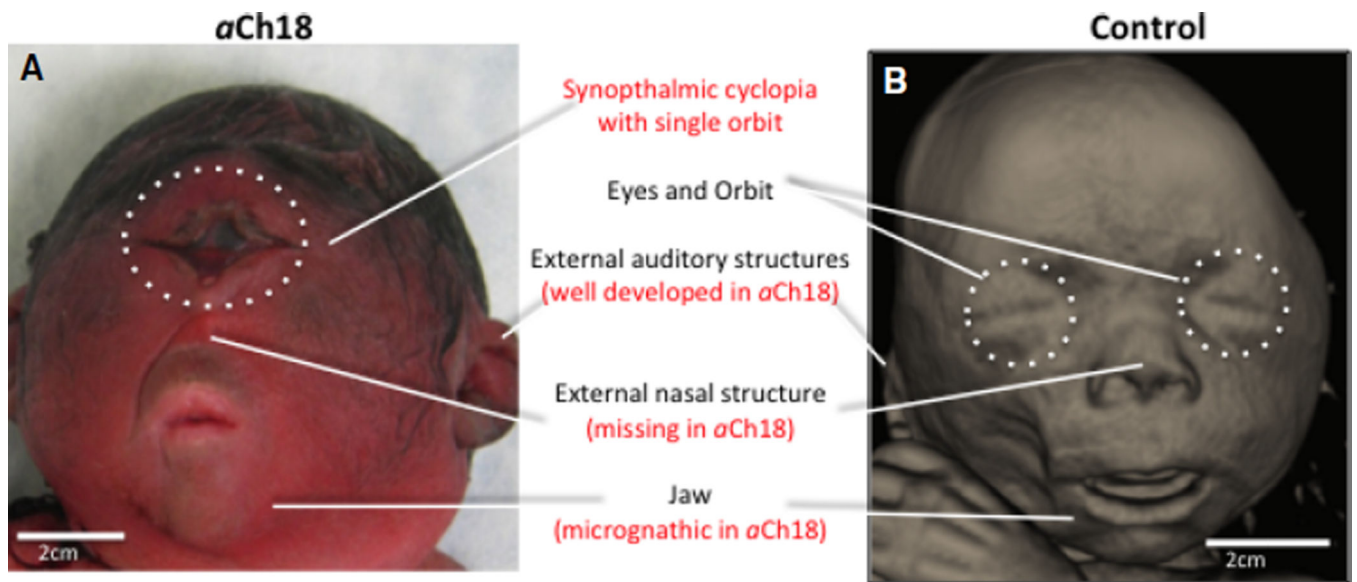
Superficial view of the facial features of a cyclopic HPE fetus and age-matched control. (A) Macroscopic view of the 28-week T18-like aberrant Ch18 (*aCh18*) fetus with a fused orbit, missing nasal structure, micrognathic jaw and well-developed external auditory structures. (B) 3D reconstruction of CT slices of age-matched control fetus showing appropriate development of superficial face at 29 weeks of gestation.
